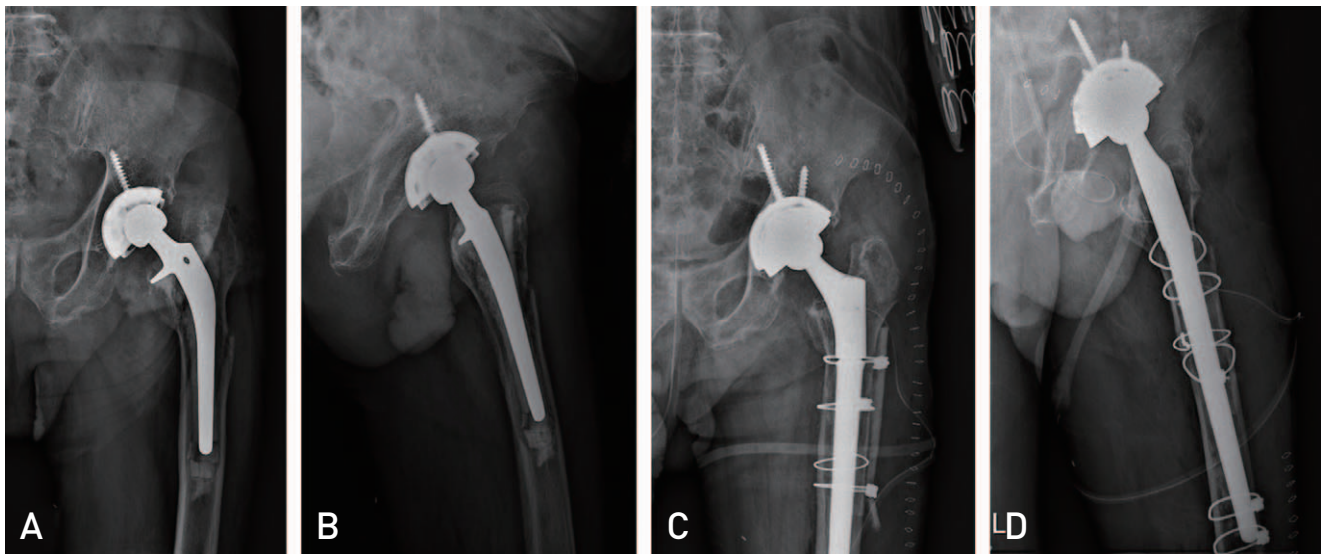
(A, B) Simple radiographs of an 86-year-old male patient who underwent primary total hip arthroplasty 25 years ago due to thigh pain after a simple fall. Periprosthetic fracture of a cemented stem in addition to loosening with poor bone stock, and wear of acetabular cup polyethylene was detected. (C, D) Revision total hip arthroplasty was performed using a cementless long stem with wires, cables, and strut allograft strut bone with a cup change to a dual-mobility system.
